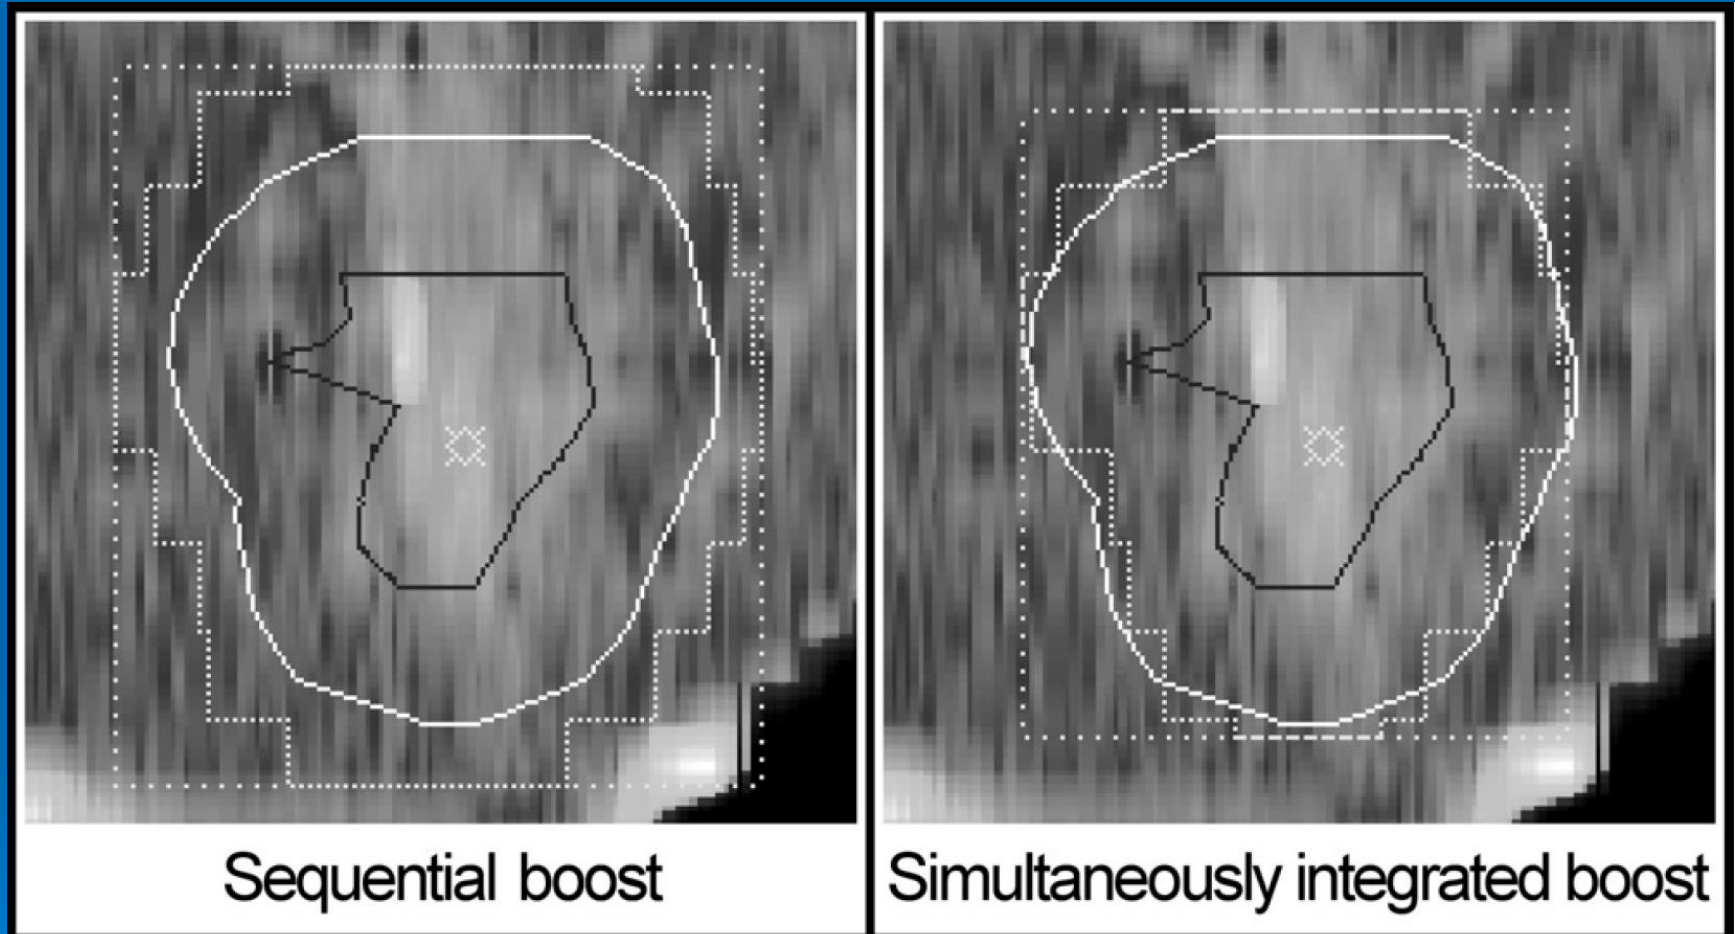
Reconstructed radiograph from boost beam's-eye-view with sequentially planned and simultaneously integrated boost. With simultaneously integrated boost technique, multileaf collimator shielding (short dotted lines) can be applied without use of margins around boost planning target volume (white solid line), resulting in substantial reduction of excess volumes irradiated.
